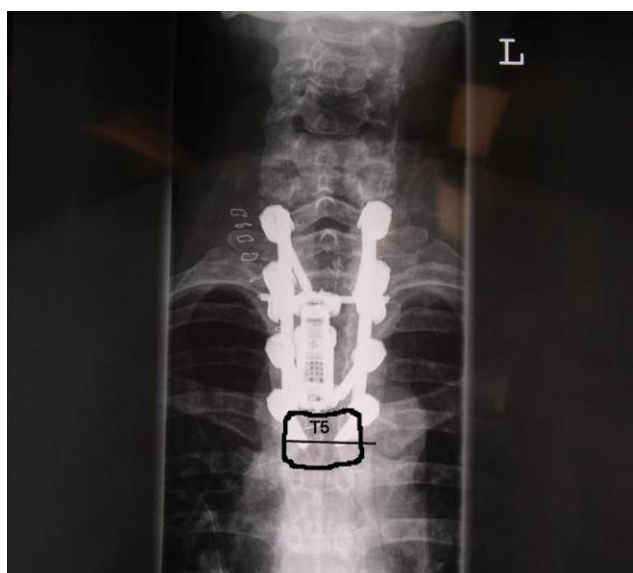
Postoperative radiograph shows use of Synex (Synthes Spine, Welwyn Garden City, United Kingdom) and cervical spine locking plate for fractured T3 vertebral body and low anterior cervical approach where line intersects T5 vertebral body. Posterior pedicle screw instrumentation was used to supplement anterior fixation. Reproduced with permission from: Lakshmanan P, Ahmed S, Al-Maiyah M, Lyons K, Davies PR, Howes J, Ahuja S. The low anterior cervical approach to the upper thoracic vertebrae: a decision by preoperative MR imaging. *Diagn Interv Radiol.* 2007;13(1):30-32.
